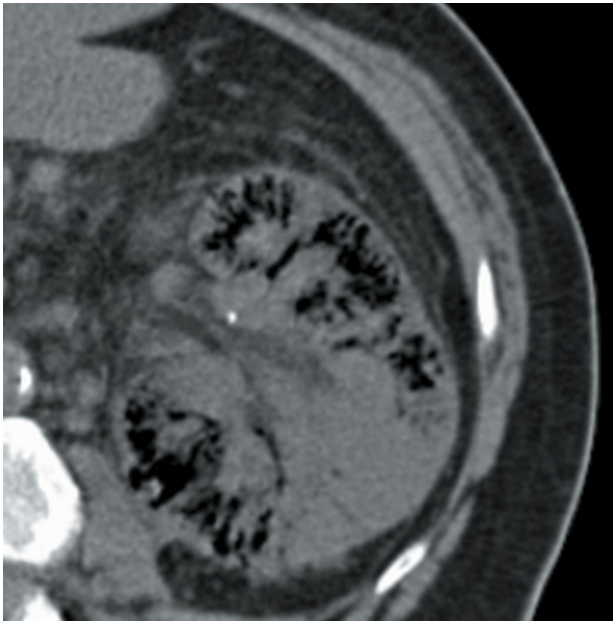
Axial CT scan image of left kidney reveals emphysematous pyelonephritis.
